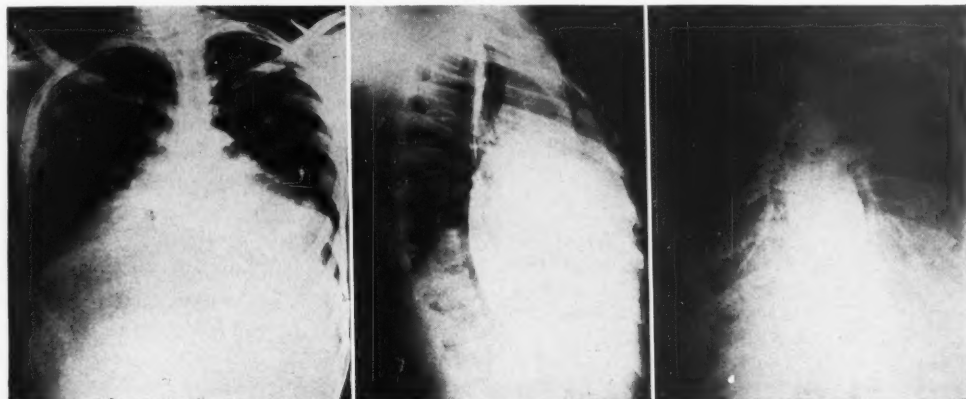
X-ray films before operation. These demonstrate the size and shape of the mass, as well as the normal size of the heart within the tumor as shown by the angiocardigram.
